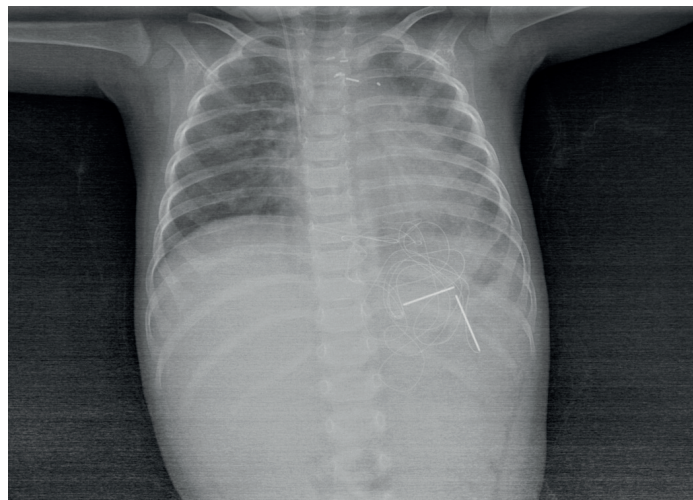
Chest radiograph of this patient before hospital discharge
